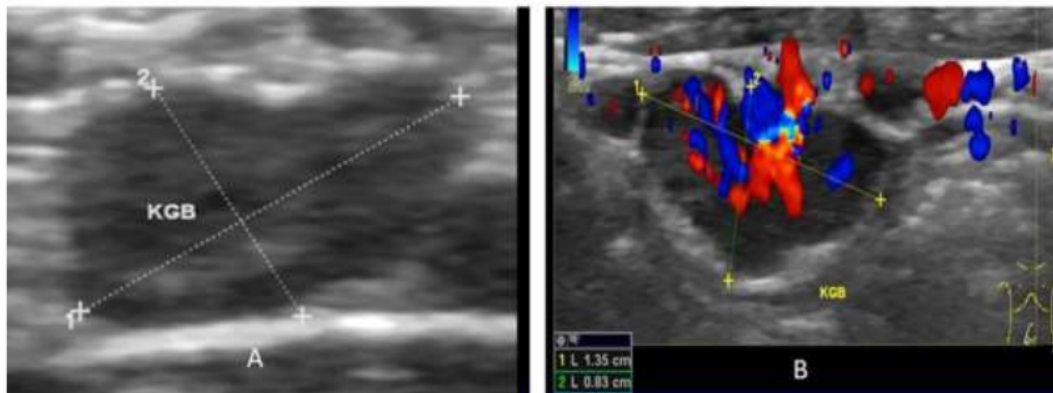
Enlarged nodes, Gray-scale ultrasound (A)
